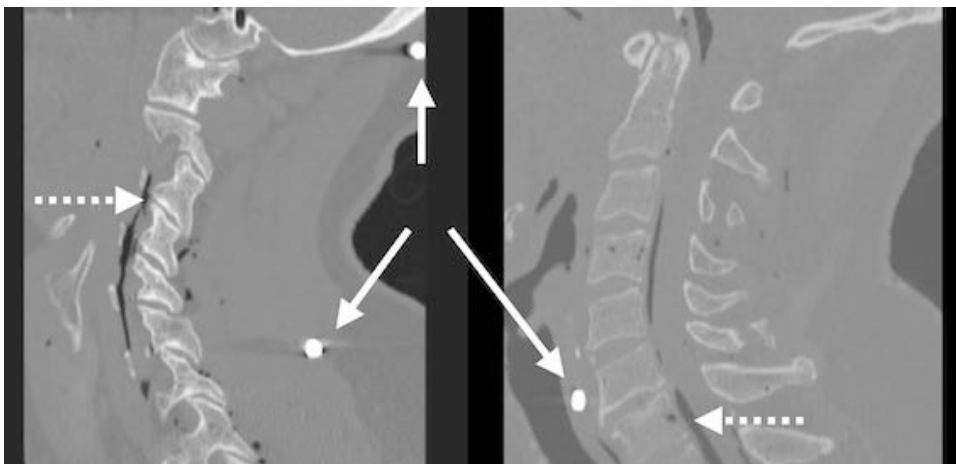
Computed Tomography scans after testing of cylindrical FSPs (solid arrows) into the neck of a post mortem human subject normal human anatomical relationships. Note inclusion of air (dashed arrows) post mortem that could mistakenly be assumed to be due to the passage of the projectile.
